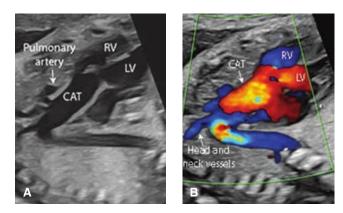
Truncus arteriosus. Grayscale (A) and color Doppler (B) images depict a single, large outflow tract. The common arterial trunk (*CAT*) overlies a ventricular septal defect (*arrowhead*) and gives rise to the head and neck vessels and pulmonary arteries. LV = left ventricle; RV = right ventricle. (Reproduced with permission from Paul Mallamaci, RDMS.)
